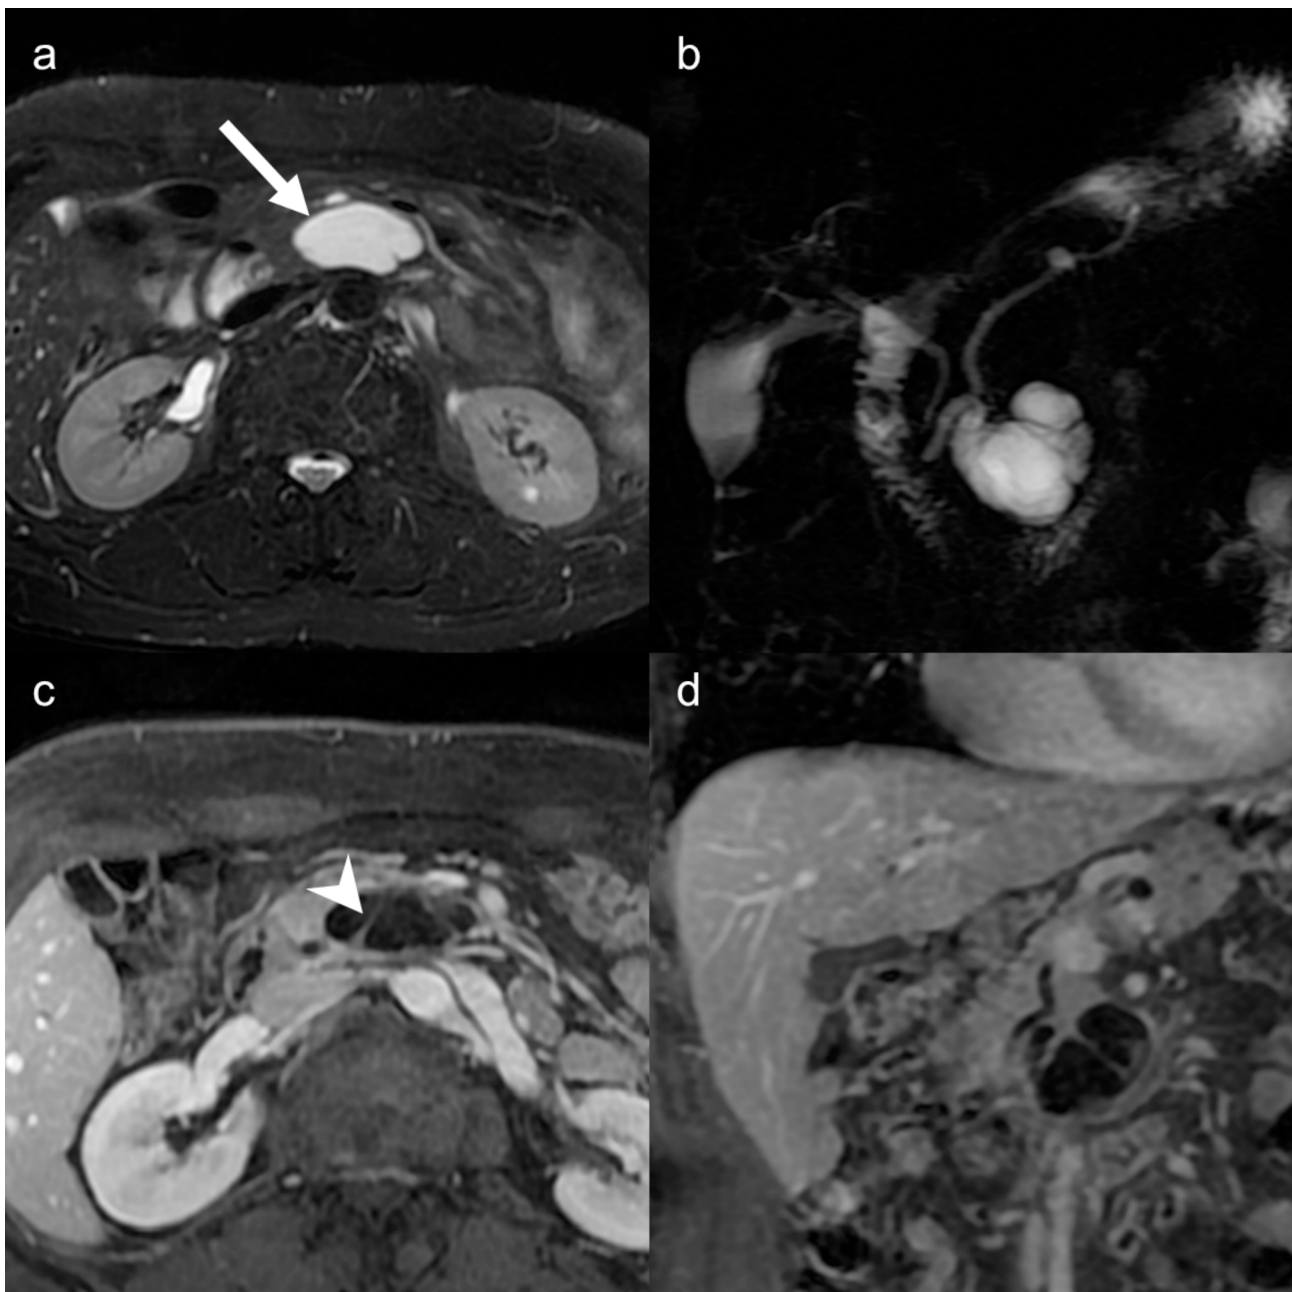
Branch-duct IPMN in a male patient. MRI on axial T2-weighted image (a) and MRCP (b) show a cystic lesion in the pancreatic head (arrow) in connection with the main pancreatic duct. Internal enhancing septa are observed on axial (c) and coronal (d) post-contrast images (arrowhead).
